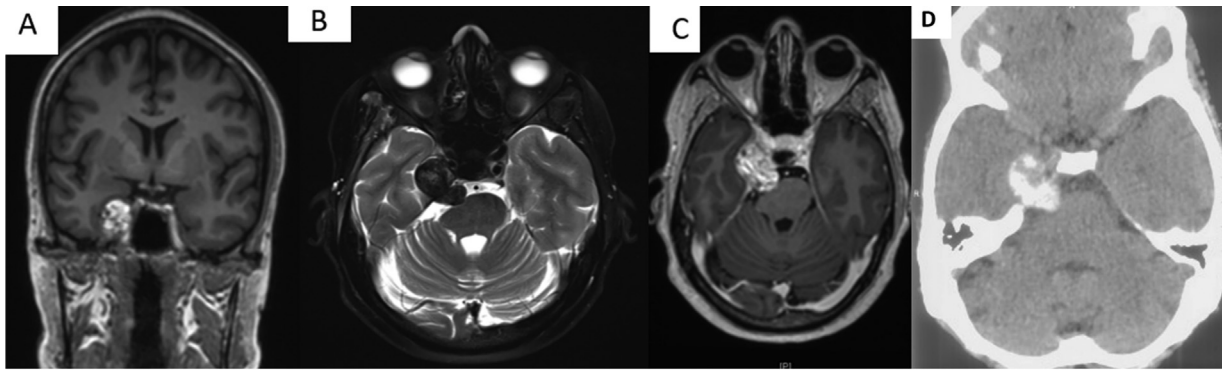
Magnetic resonance (MR) imaging showing T1 hyperintense mass in posterior cavernous sinus in coronal section (A). The mass was T2 hypointense and extended from the right Meckel's cave to the posterior cavernous sinus (B). The mass was nonenhancing (C) and had areas of hyperdensity on plain computed tomography (CT) imaging (D).
